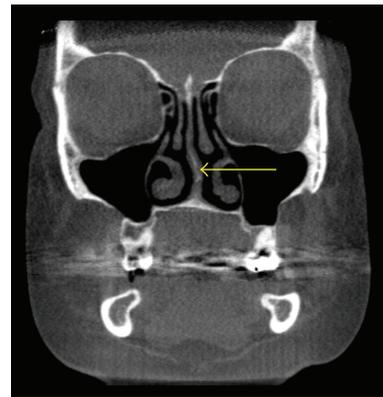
Coronal CT scan demonstrating left nasal septal deviation (arrow). No concha bullosa or sinusitis is evident.
